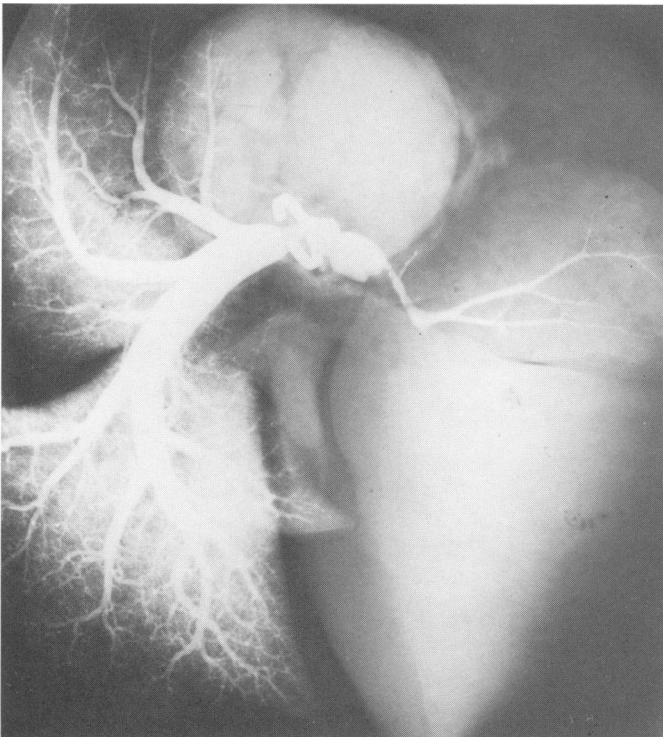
Radiography of heart and lungs of M38. The left pulmonary arterial tree does not fill, due to thrombosis at the anastomosis. Note ring of ameroid constrictor on the right pulmonary artery.
